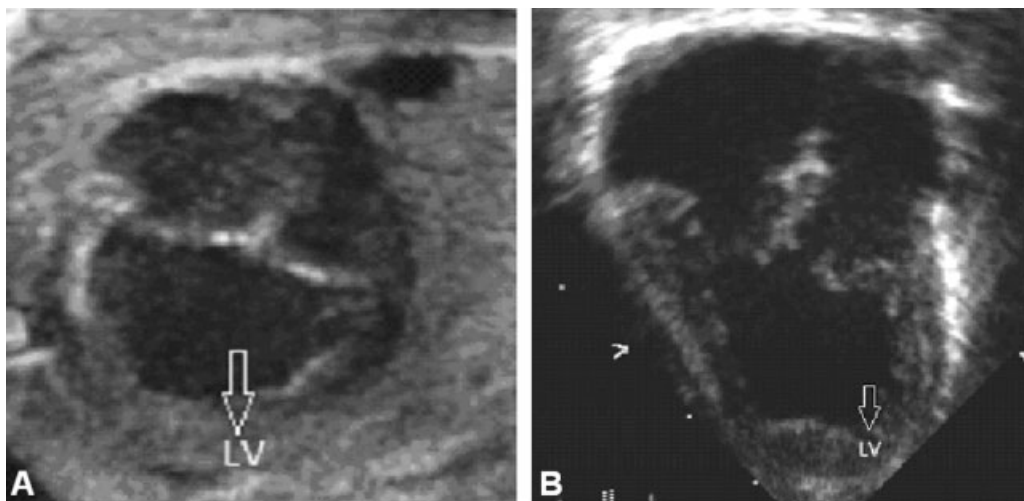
(A) Two-dimensional fetal echocardiogram at 24 weeks of gestation. (B) Two-dimensional transthoracic echocardiogram at birth. Both images demonstrate double-inlet left ventricle (two atrioventricular valves empty in a smooth walled left ventricle).
